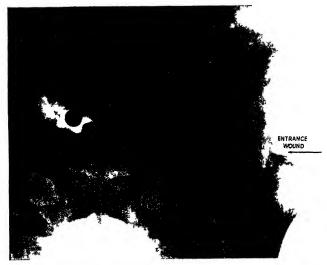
Fig B—Radiograph of pelvis, showing shrapnel bullet in the bladder. It was eventually localized in that viscus, and when removed was coated with urates
